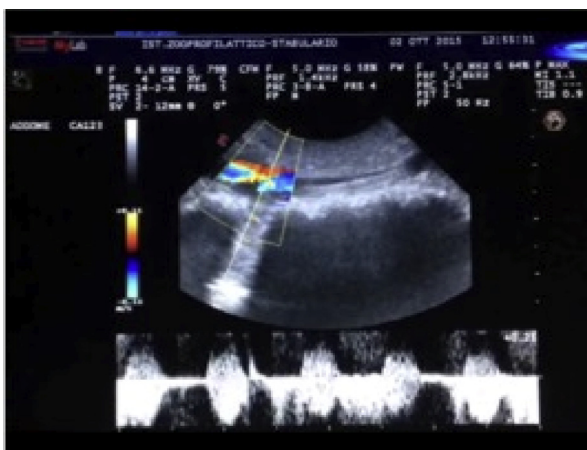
Doppler ultrasound performed immediately after surgery, showing the patency of the anastomosis, with a typically turbulent flow.
